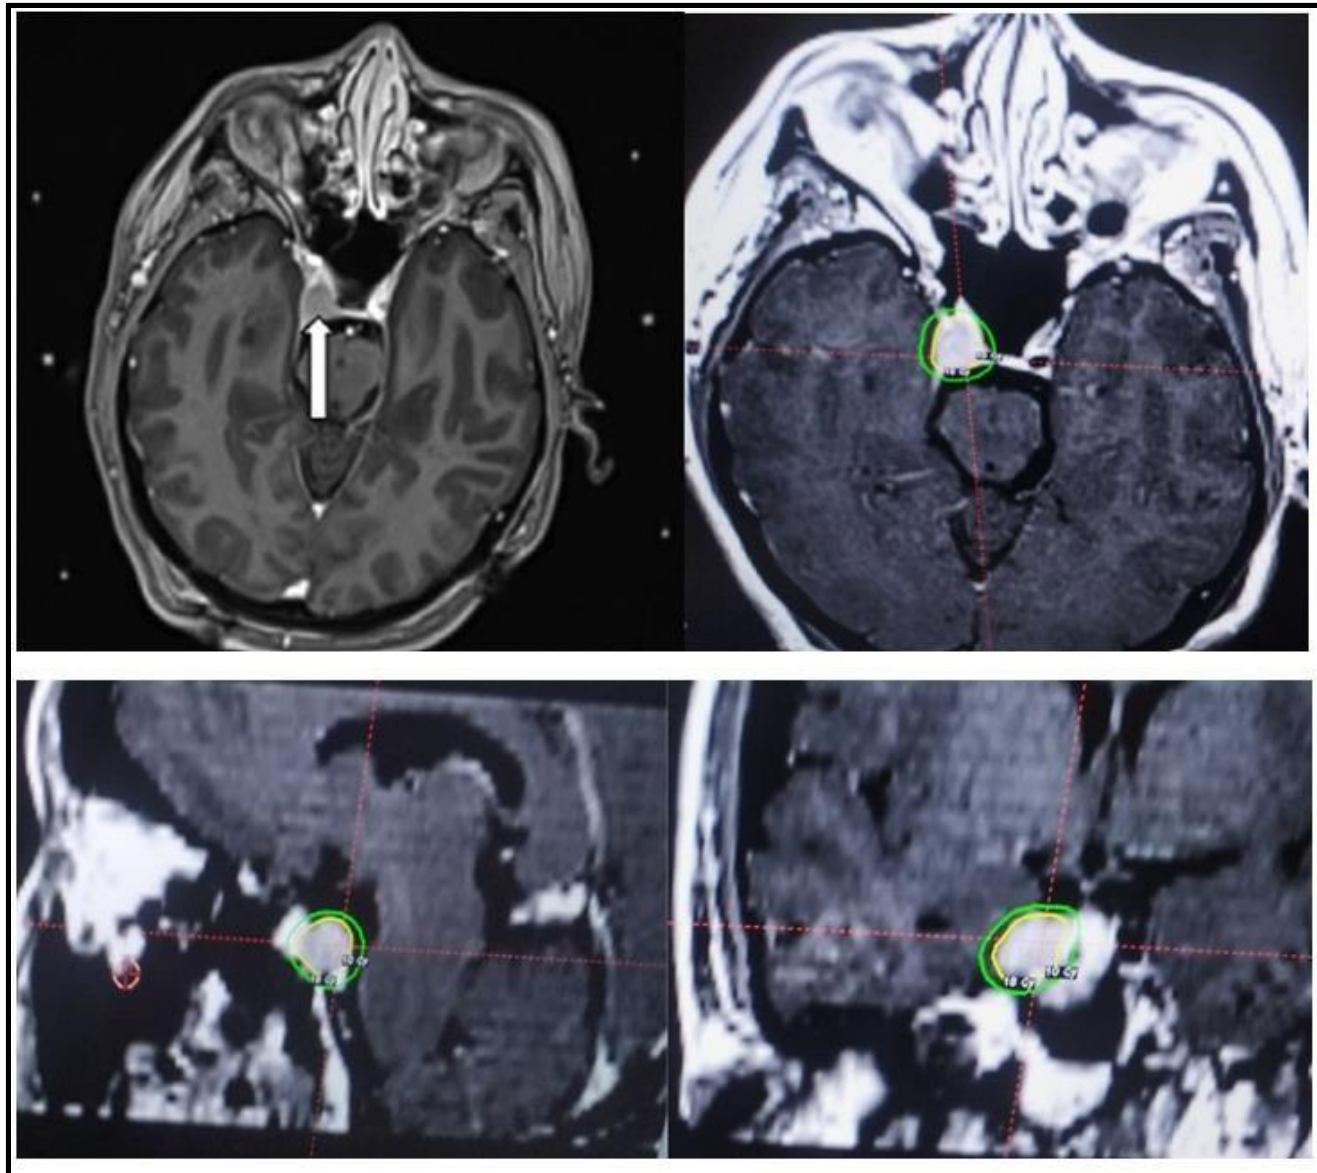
MRI performed for Gamma knife radiosurgery planning in May 2018.
